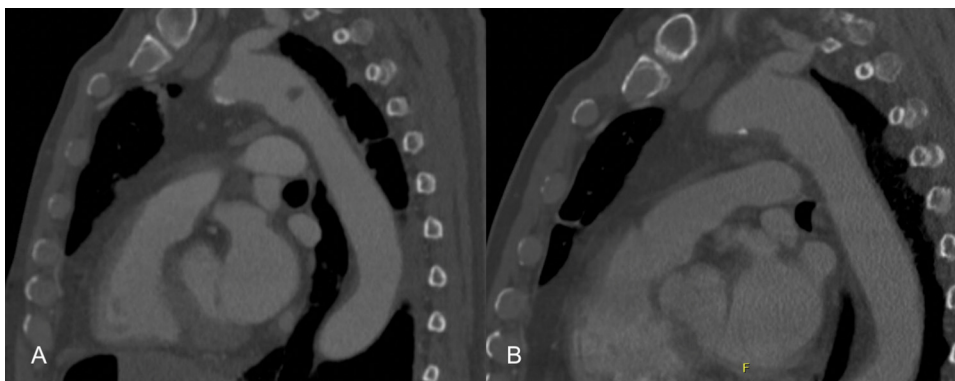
(A) Computed tomography angiography (CTA) revealing a 1.2 cm eccentric thrombus in the proximal descending aorta. (B) CTA performed two months following the initial scan demonstrating interval resolution of the thrombus with anticoagulation therapy.
